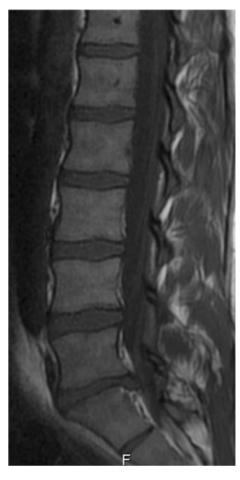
Preoperative sagittal T1 MRI of the lumbar spine showing the massive L5-S1 disc herniation
